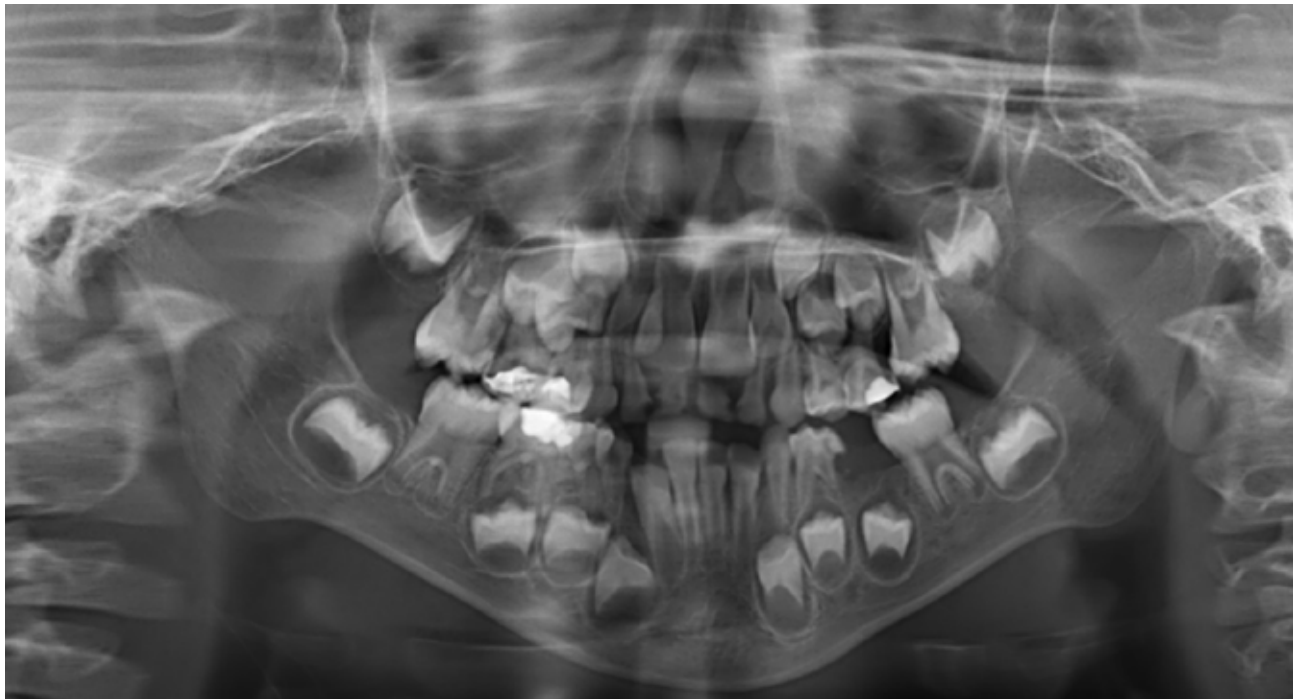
Panoramic radiograph following emergency management including extraction of tooth 75.
